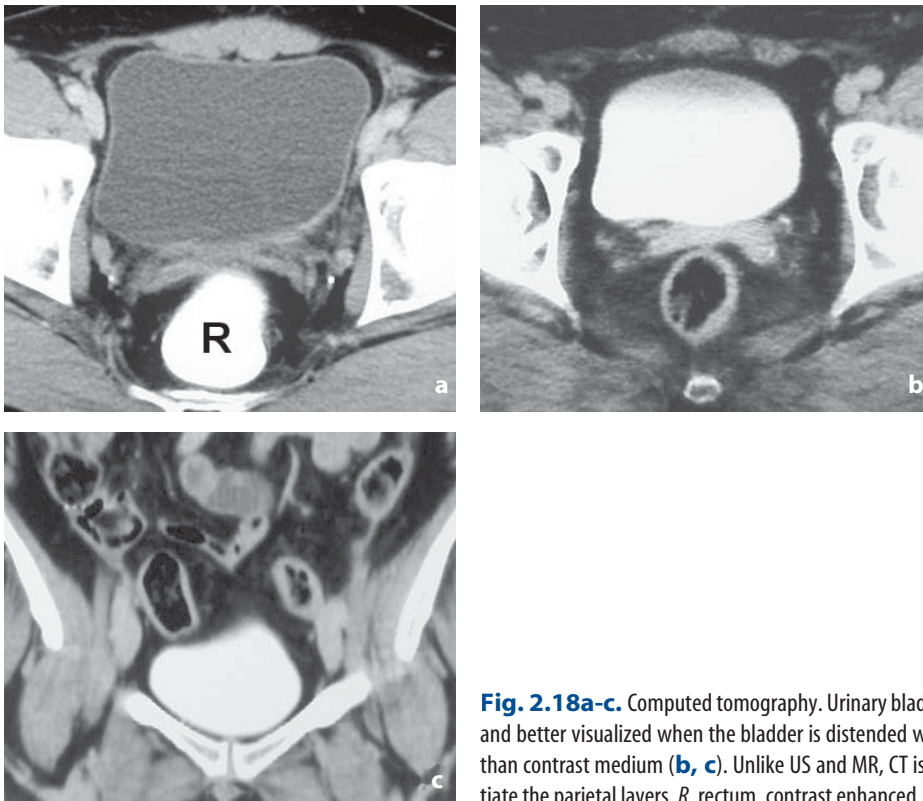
Computed tomography. Urinary bladder. The wall is thin and better visualized when the bladder is distended with urine (a) rather than contrast medium (b, c). Unlike US and MR, CT is unable to differentiate the parietal layers. *R*, rectum, contrast enhanced
